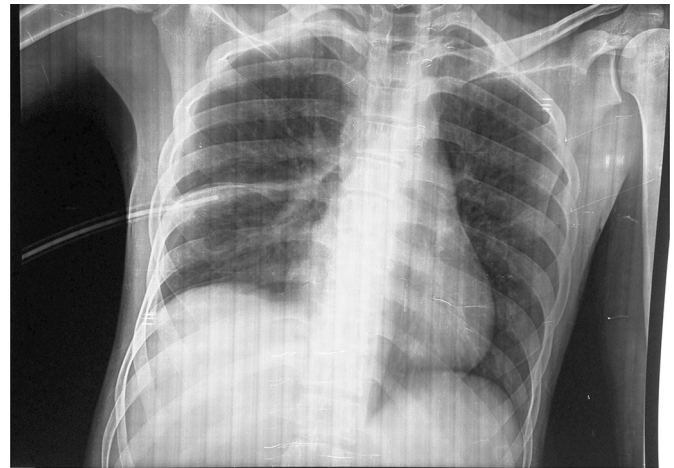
Chest X-ray demonstrated total lung reexpansion after thoracic tube insertion. Mild pleural thickness is observed.
